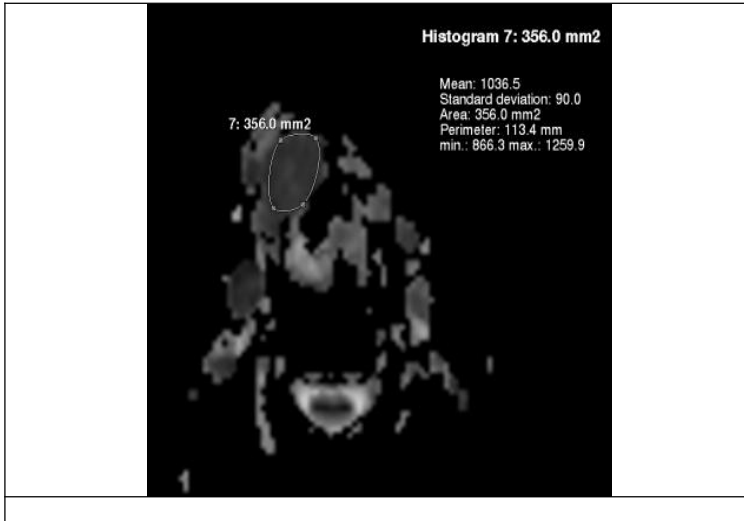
52-year-old Male patient, with enlargement of the tongue. Contrast enhanced MRI & DWI was done revealing large ill-defined infiltrative soft tissue mass centered on the epiglottis displaying low SI on axial T1WI (A), high SI on T2WI (B), heterogeneous post contrast enhancement on post contrast study (C). On
